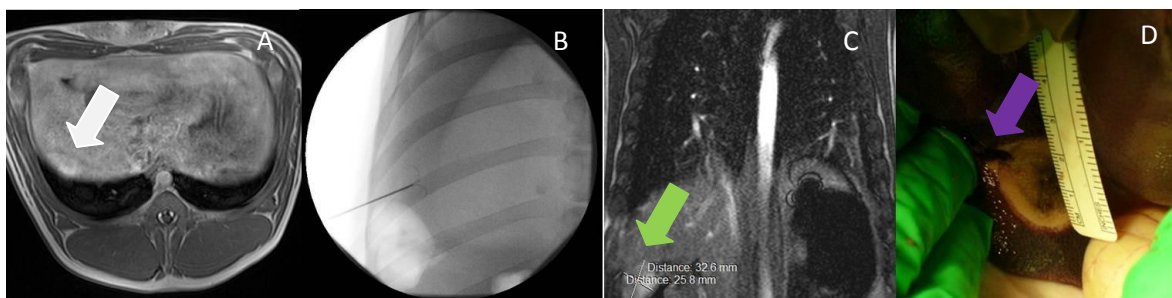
A: MR image (VIBE, transversal) used for treatment planning in the liver (white arrow) B: Needle placement in the liver (Fluoroscopy image); C: Post-ablation MRI (True FISP), showing a very large ablated area in the liver (green arrow); D: Necropsy image showing a large ablated area in the liver (purple arrow).
